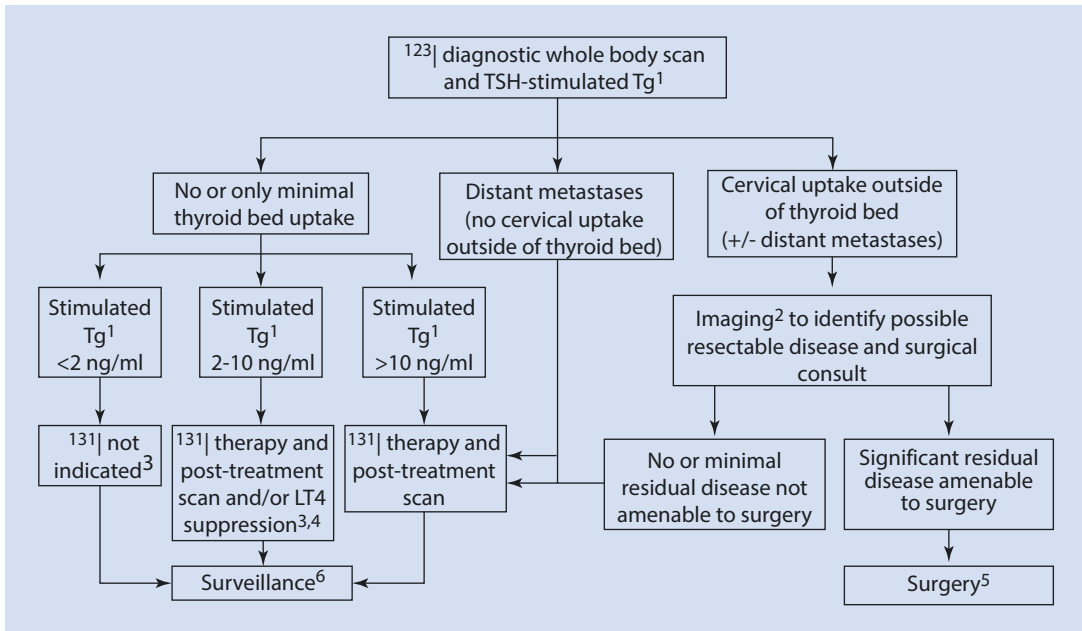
Initial management for papillary thyroid cancer in children. Preoperative staging is vital to determine therapy. RAI ablation is indicated for high-risk patients but may be deferred for low-risk patients if close follow-up is assured (see text for details). ¹Assumes a negative TgAb and a TSH >30 mIU/L; in TgAb-positive patients, consideration can be given (except in patients with T4 tumors or clinical M1 disease) to deferred evaluation to allow time for TgAb clearance (“delayed” staging). ²Imaging includes neck ultrasonography ±SPECT/CT at
